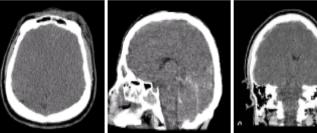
CT scan with diffuse cerebral edema and brainstern hemiation. Note obilteration of cistems and absence of grey-white differentiation
